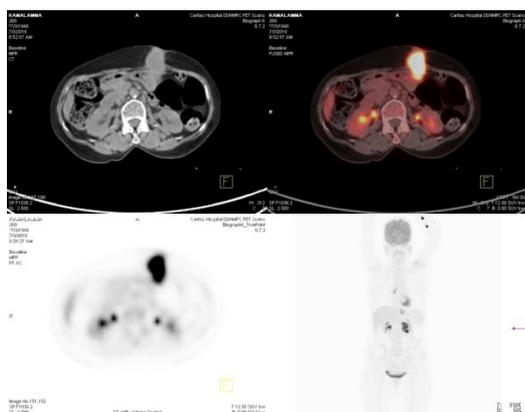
Whole body PET CT scan showing metabolically active disease at the anterior wall of stomach and soft tissue deposit in the anterior abdominal wall at the PEG site.
